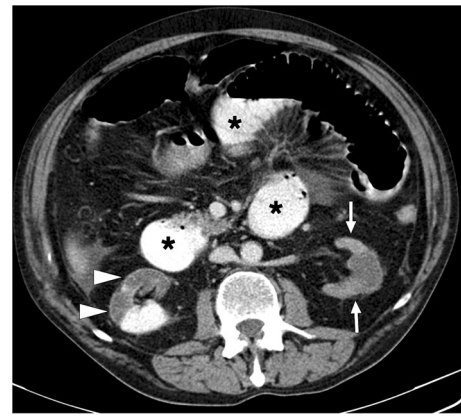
A 59-year-old male patient with known congestive heart failure and atrial fibrillation presented with abdominal distention and diffuse abdominal pain to the ER. Axial plane postcontrast abdominal CT image showed a diffuse decrease in the parenchymal enhancement of the left kidney (arrows) and a large right renal infarct with thin cortical enhancement, so-called the cortical rim sign (arrowheads). Noted were dilated small bowel loops (asterisks), which were later surgically confirmed to be secondary to intestinal ischemia
